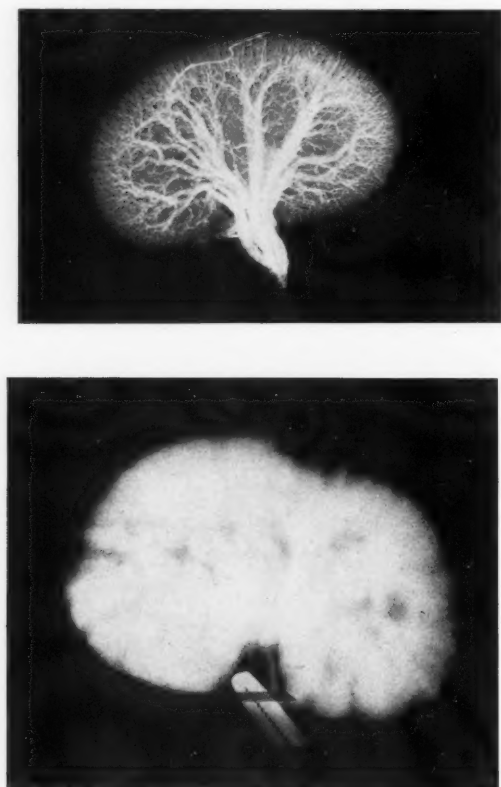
Radiograph of an injection of the venous circulation of the kidney: *a*, Sodium bromid solution; *b*, bismuth emulsion with condensed milk.
